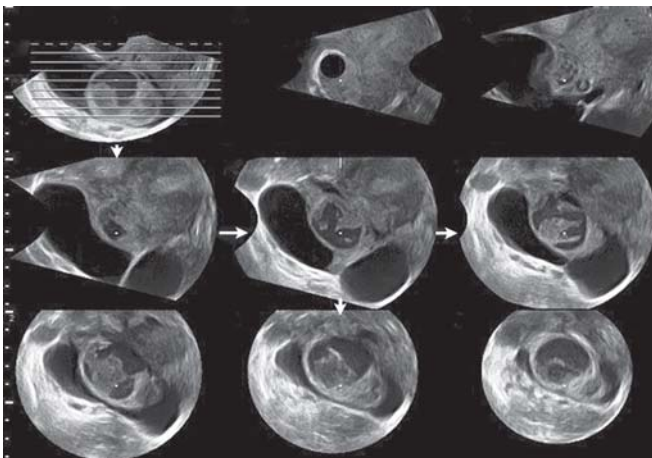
3D tomographic ultrasound imaging of the same patient as in figures 40A and B. Sequential sections show a distinct hydrosalpinx enveloping an ovary, one edge of which shows echogenic debris, confirming acute salpingo-oophoritis
